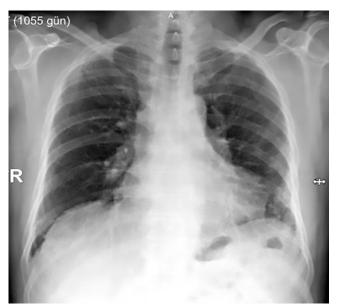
Pre-COVID posteroanterior roentgenogram
